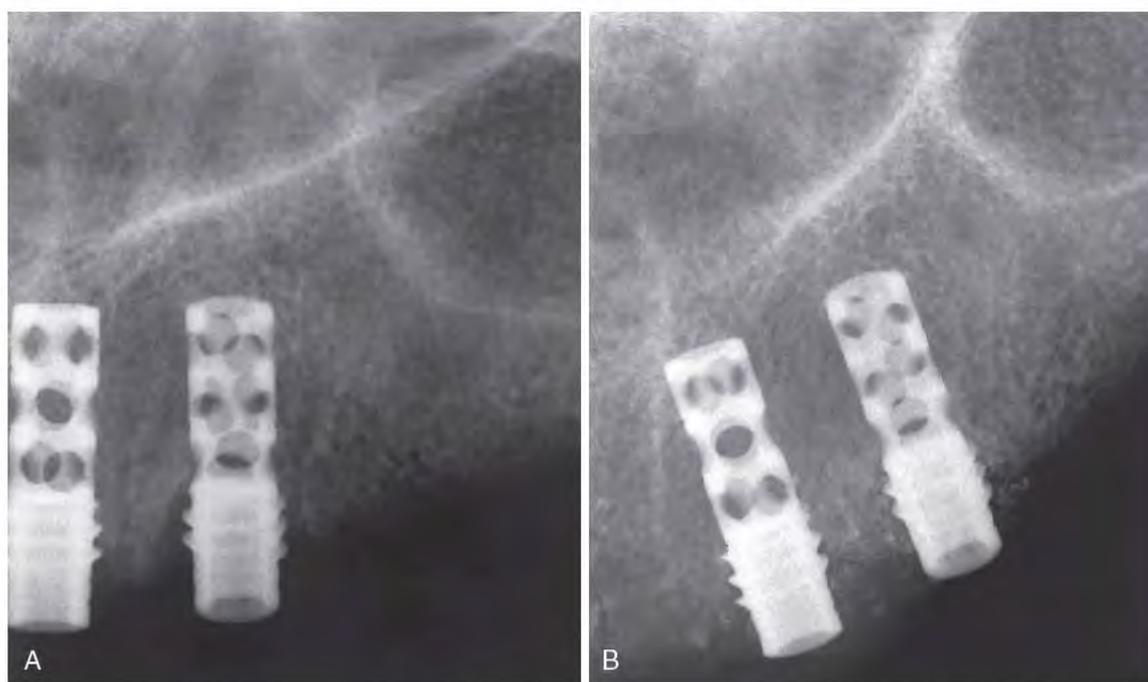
Preoperative (A) and postoperative (B) radiographs of two Core-Vent implants repaired with hydroxyapatite (HA) in a classic periodontal manner.
